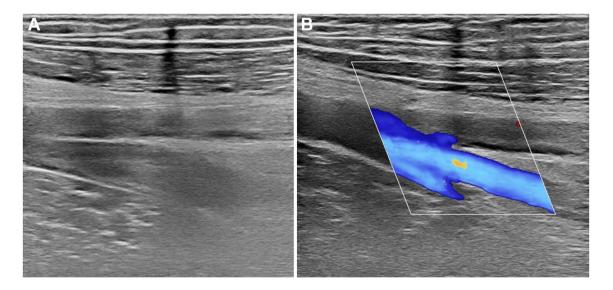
A Grayscale ultrasound examination of common femoral vein demonstrating enlarged, non-compressible vessel, a typical example of DVT. B ColorDoppler examination of right deep and superficial
